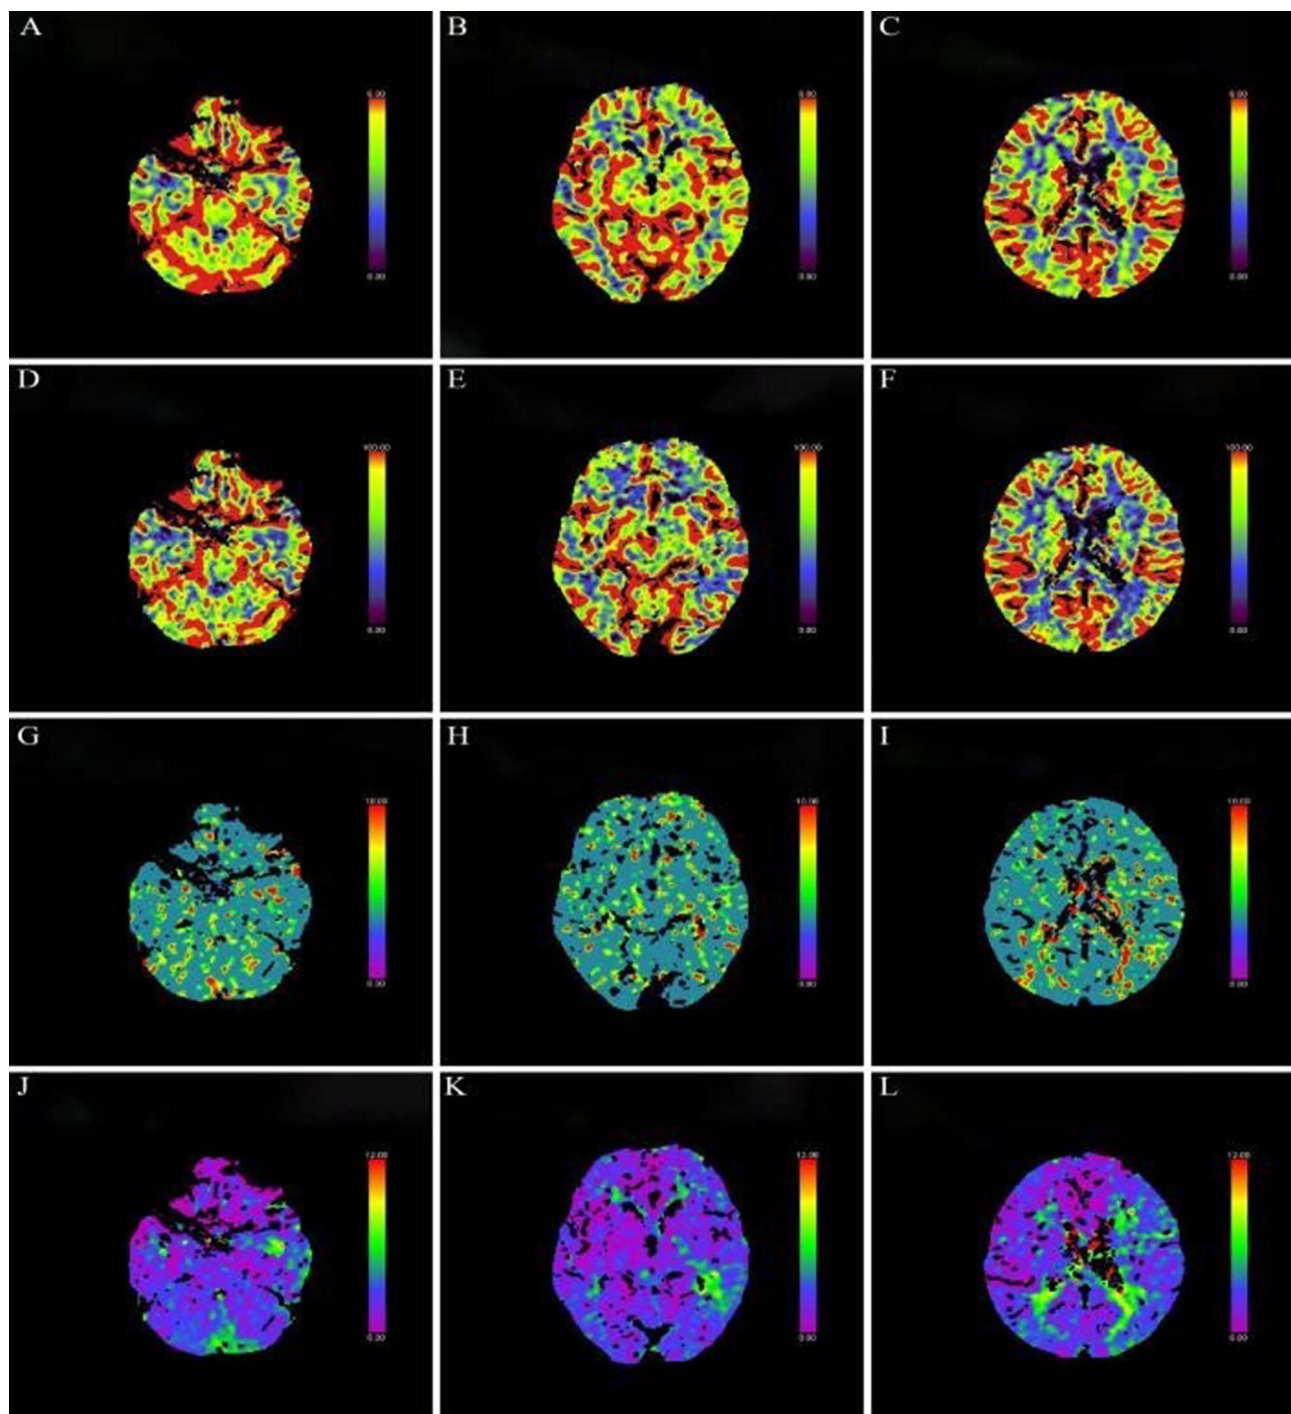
The same patient as Figure 4. Postoperative computed tomography perfusion (CTP) imaging showed that there was no significant difference in bilateral cerebral blood volume (CBV) (A–C), cerebral blood flow (CBF) (D–F), mean transit time (MTT) (G–I) and time to top (T-Max) (J–L).
